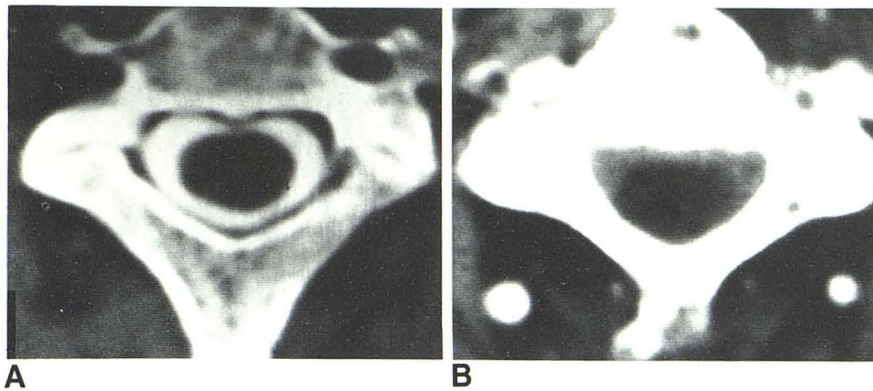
A, CT scan with intrathecal metrizamide but no intravenous contrast administration at C3 level 4 weeks after fig. 1. Midline bony spur and subtle cord enlargement. B, 1 day later with intravenous contrast administration. No pathologic contrast enhancement.
